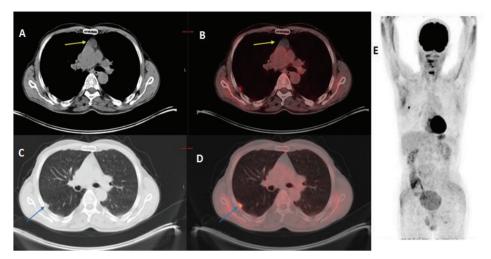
We present a case of a 62 years old man with a history of giant cell tumour of lung. 18F-fluorodeoxyglucose (FDG)-positron emission tomography/computed tomography (PET/CT) demonstrated abnormal uptake in the malignancy suspected nodular lesion in right lung upper lobe (C and D, blue arrow). The patient underwent right lung wedge resection and final diagnosis was pulmonary giant cell carcinoma with visceral pleural invasion. Axial thorax CT image (A), fused PET/CT images (B, D), axial parenchyma window CT image (C), wholebody maximum intensity projection (MIP) image (E).
